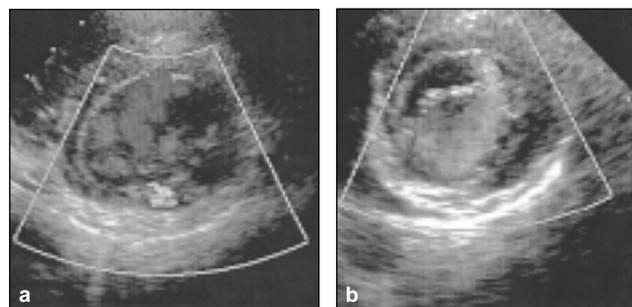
Two-dimensional echocardiogram short axis view at mitral valve level: (a) mitral regurgitation through posteriomedial commissure, (b) mitral regurgitation through anterolateral commissure.
